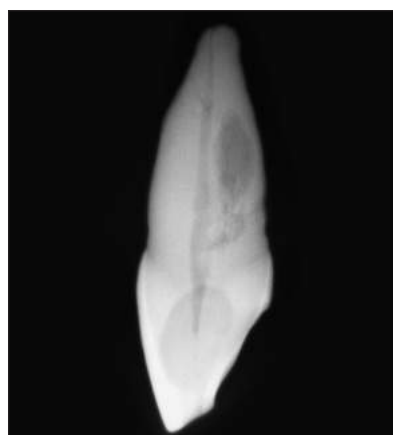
A proximal radiograph of the extracted tooth demonstrates a resorptive lesion palatal to the intact root canal. Figure 3A demonstrates that the coronal extent of the resorption is distal to the root canal.
